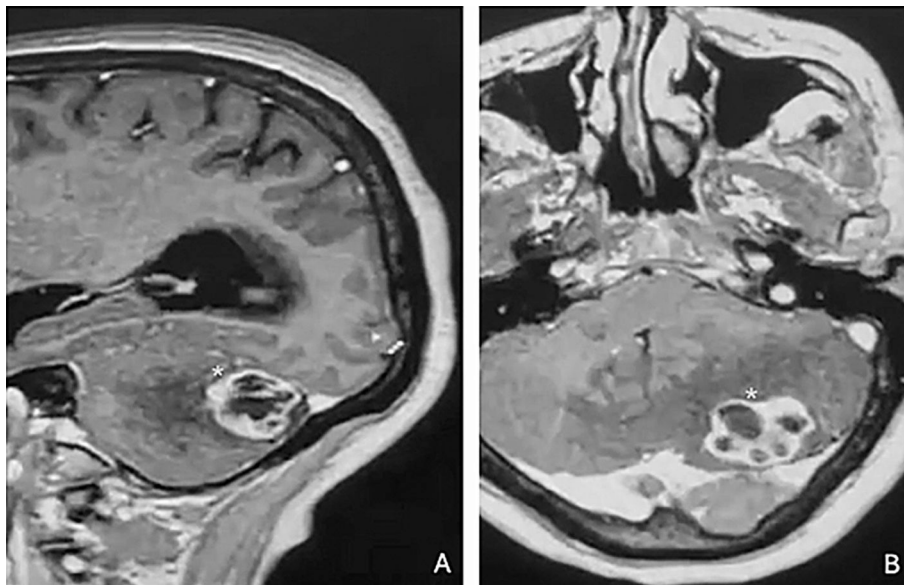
Brain MRI in parasagittal (A) and axial (B) sections shows a lesion in the left cerebellar hemisphere measuring approximately 6 × 3 cm (asterisks). T1 (A) shows heterogeneous enhancement, with a cystic component and perilesional edema (asterisk). T2 (B) shows the same lesion as hyperintense (asterisk), with compression of adjacent structures.
